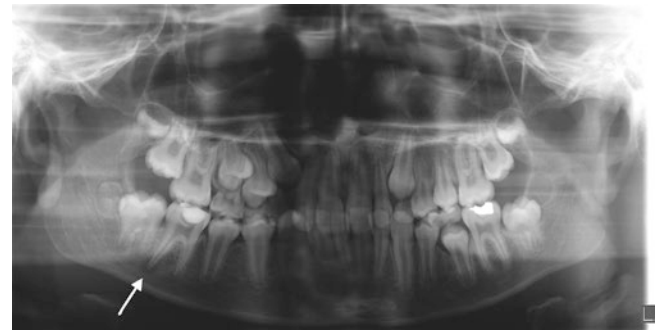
Periapical dental abscess. Orthopantomogram (OPT) shows lucency around the root of the right lower first molar tooth (arrow), in keeping with a periapical dental abscess
